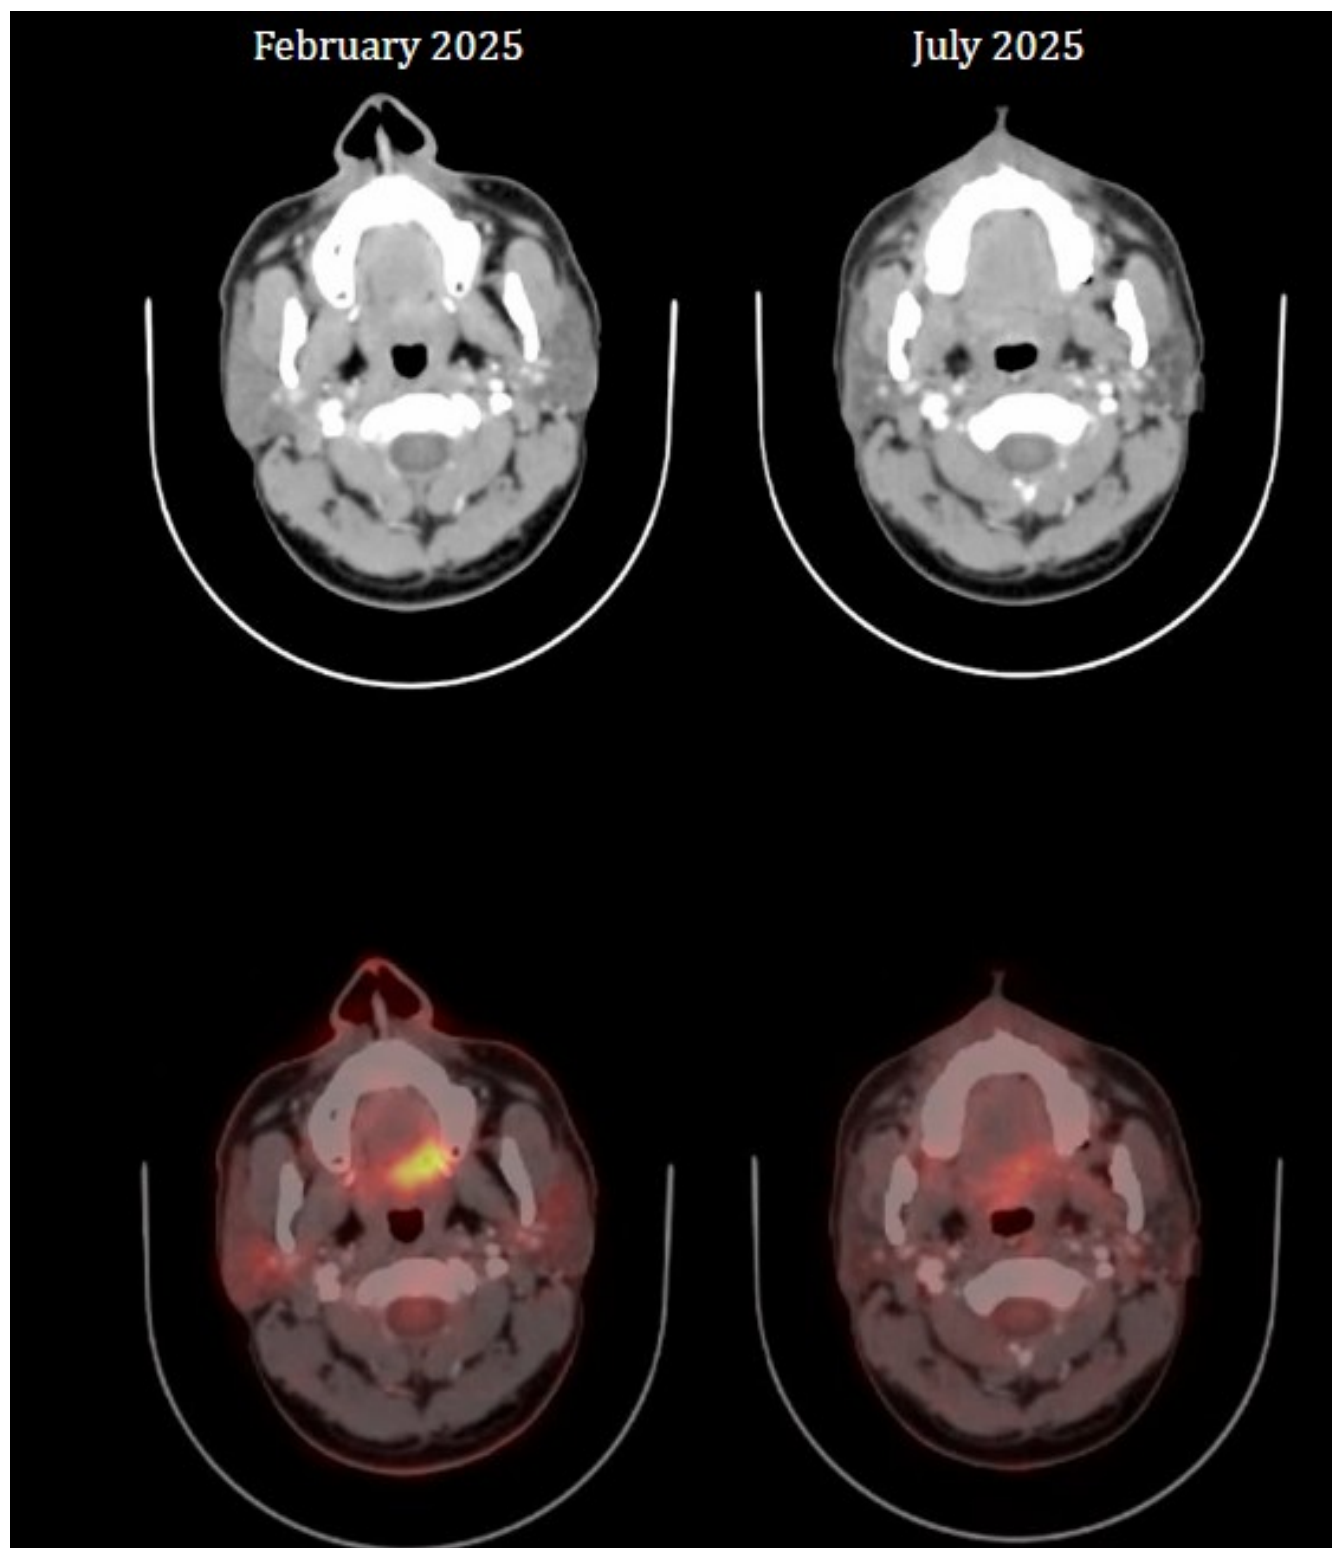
Axial CT and fused PET/CT images. The left panel (February 2025) shows a lesion involving the left side of the palate. The right panel (July 2025) demonstrates mild, non-specific metabolic activity at the same site, likely representing post-treatment inflammatory changes.
